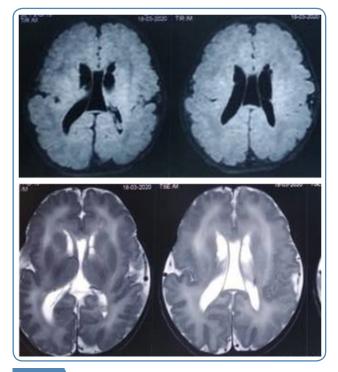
MRI brain findings in Zellweger syndrome 6A.T2 weighted MRI brain axial view showing germinolytic cysts 6B. T1 weighted MRI brain axial view showing diffuse polymicrogyria
